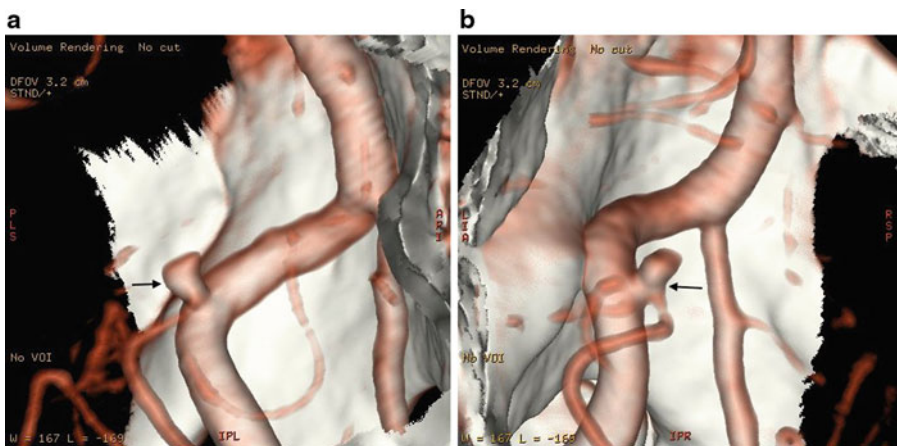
(a) 3D reconstruction of computed tomography angiogram in a patient with a small, 2.6 mm, posterior inferior cerebellar artery aneurysm (*arrows*), showing a detailed profile of the aneurysm. (b) Rotational
